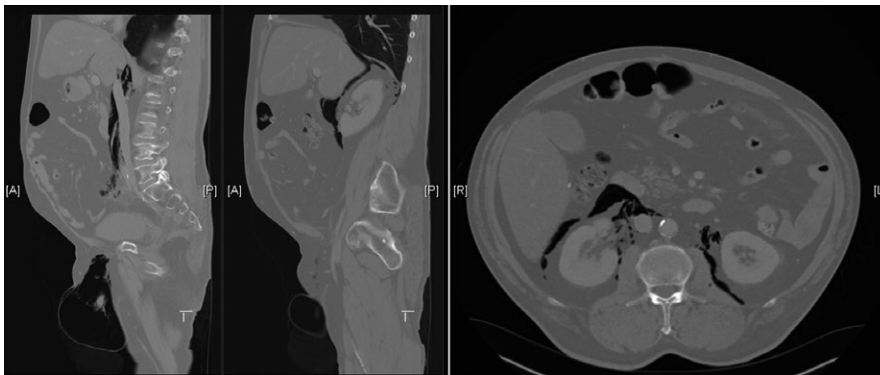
Postoperative CT scan—retroperitoneal
